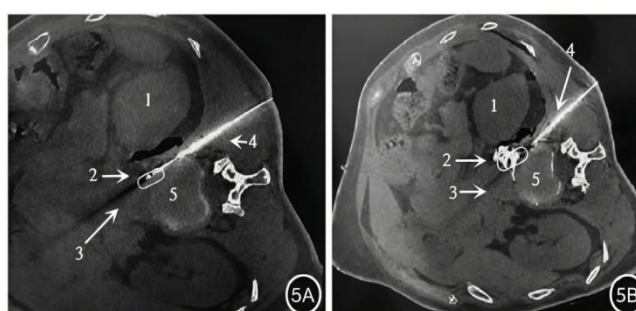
CT guided SNN puncture injection process [22].
